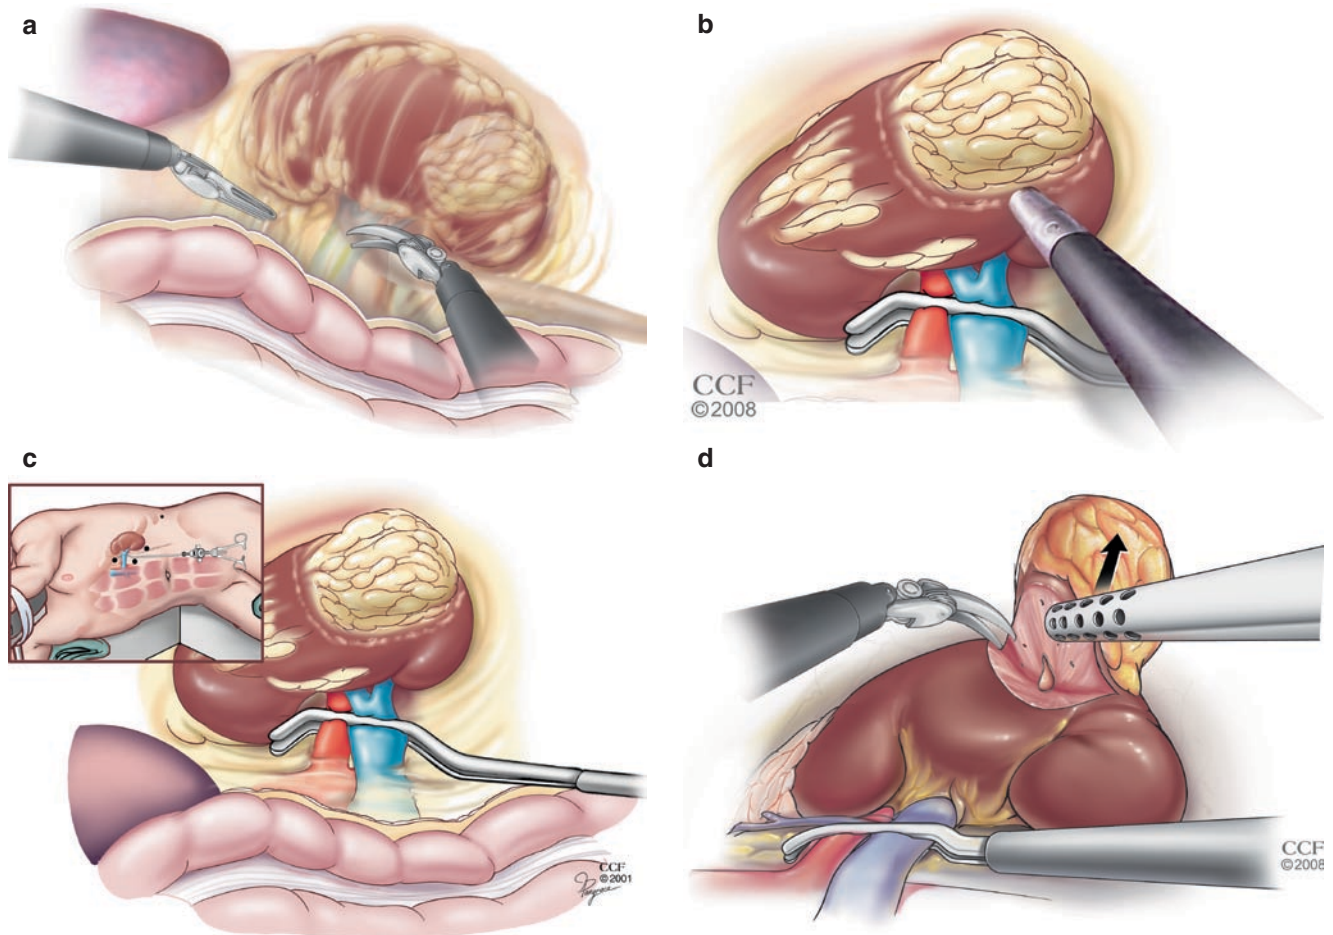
Surgical steps of robotic-assisted laparoscopic partial nephrectomy including mobilization of the colon (a), intraoperative ultrasonographic examination to identify and score the boundaries of the tumor (b), prior to hilar clamping (c), and excision of the tumor (d)
